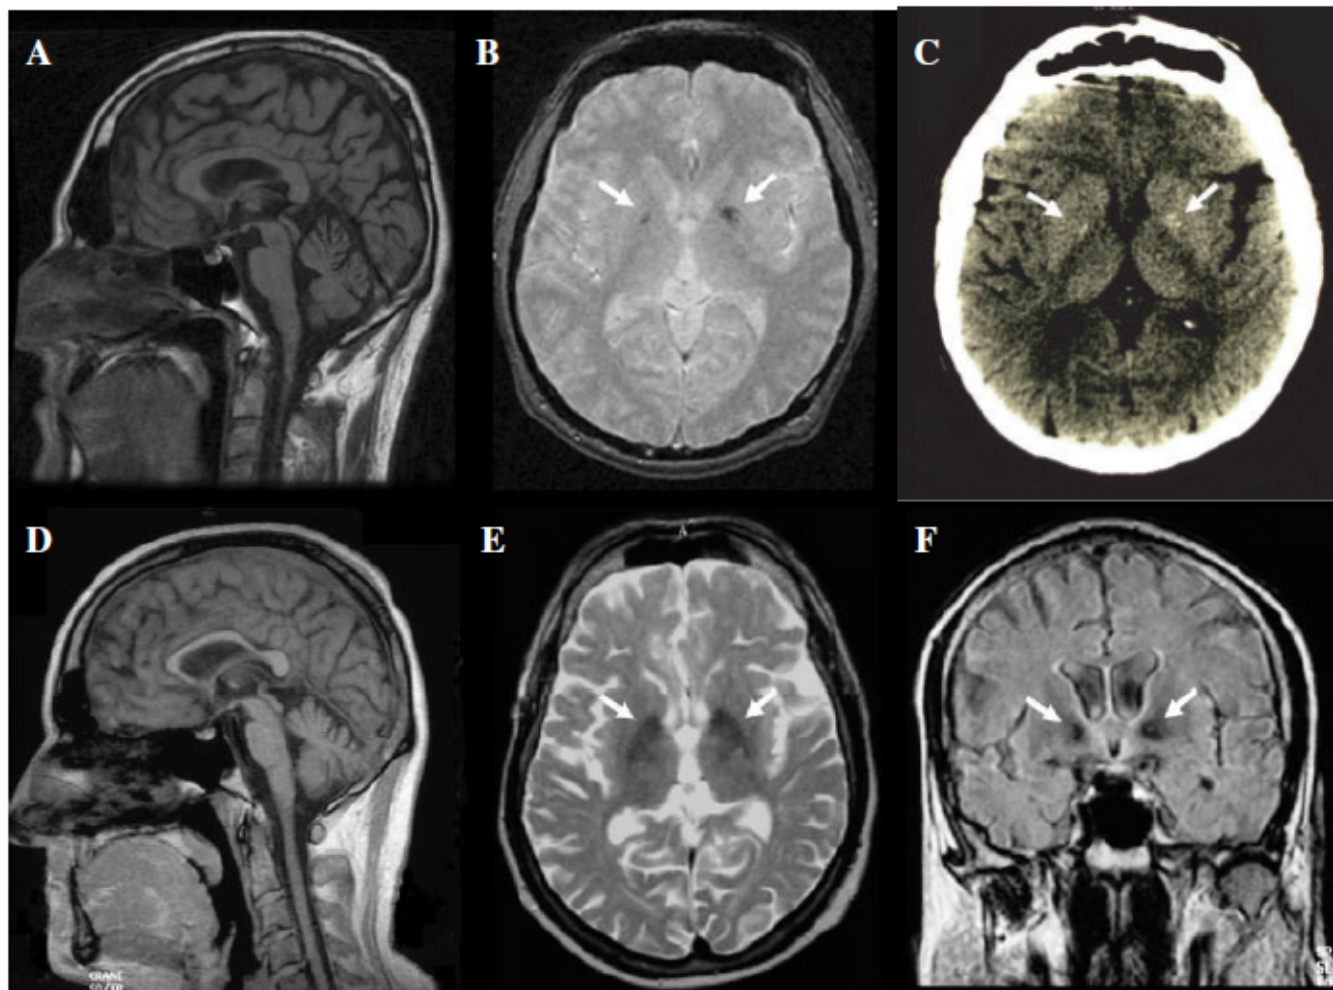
Brain MRI and CT scan. (A), (B) and (C) refer to the proband from Family I. In panel A a mid-sagittal T1-weighted brain MRI scan shows variable degrees of atrophy affecting cerebral cortex, brainstem and cerebellum. In panel B the axial gradient echo MRI scan shows bilateral hypointensity within the globi pallidi (arrows), which is detected as depositions of calcium in the CT scan (arrows) shown in panel C. (D), (E) and (F) refer to the proband from Family 5. In panel D a mid-sagittal T1-weighted brain MRI scan shows a thin corpus callosum as well as brainstem and cerebellar atrophy. In panel E the axial T2-weighted scan shows bilateral hypointensity within the globi pallidi, which are also detected in the coronal scan (arrows) shown in panel F.
